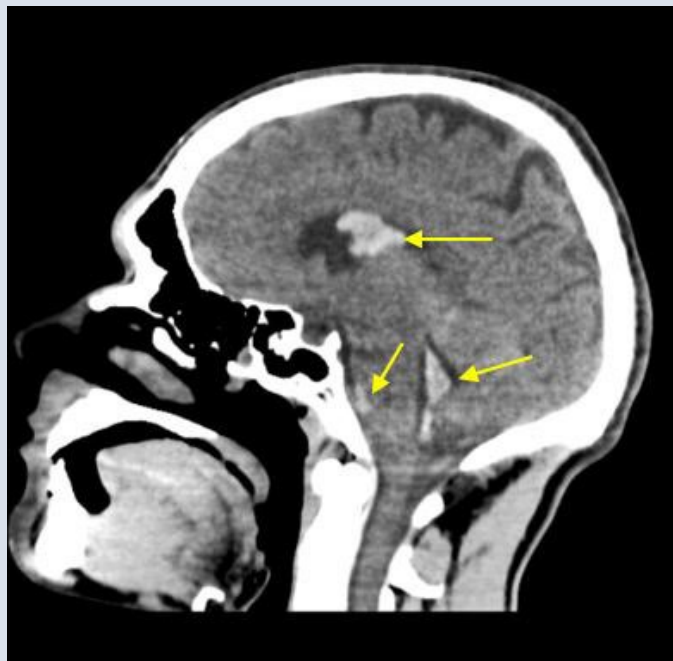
A - Noncontrast head CT shows a right-sided cerebellar subarachnoid hemorrhage, blood within all four ventricles and a right-sided parenchymal pontine hematoma.
